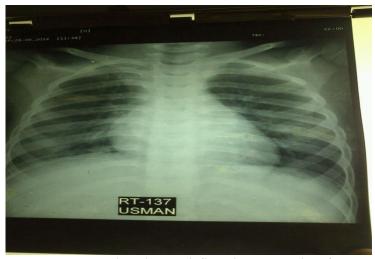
Chest X-ray cropped showing bilateral infiltrations suggestive of Bronchopneumonia.
